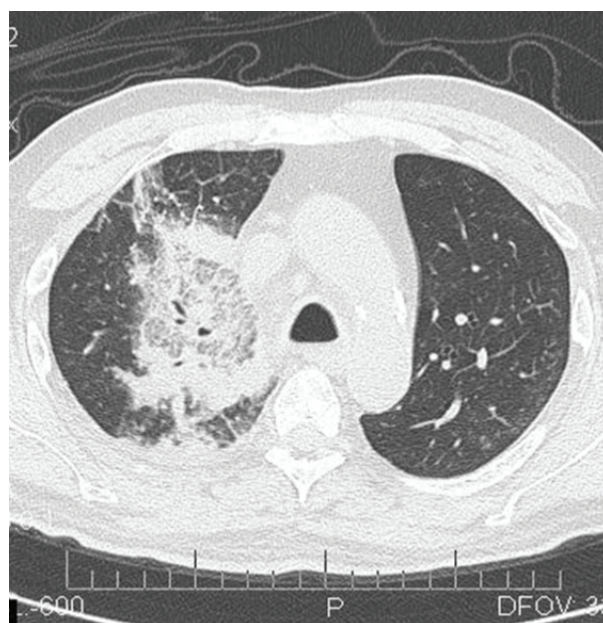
CT image of pulmonary mucormycosis with the reverse halo sign
